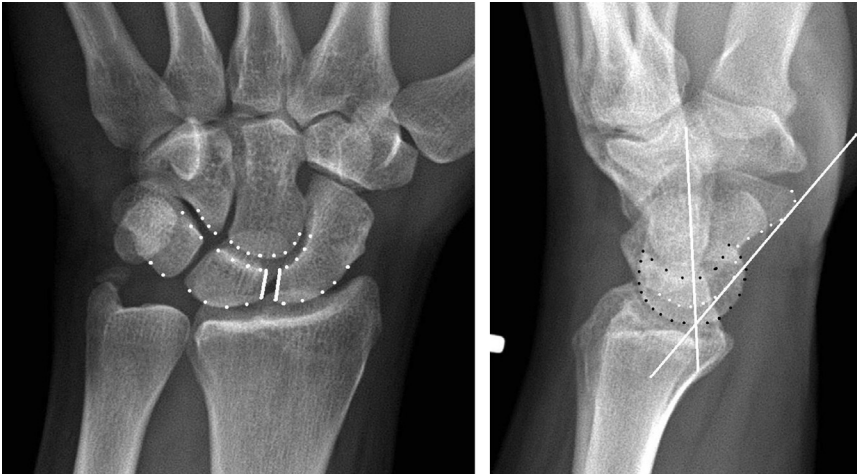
Wrist posteroanterior (*left*) and lateral (*right*) radiographs. Posteroanterior smooth carpal alignment (*dotted lines*) of Gilula's lines and scapholunate (SL) interval (normal, <4 mm). The lateral-SL angle is normally 30° to 60°.
